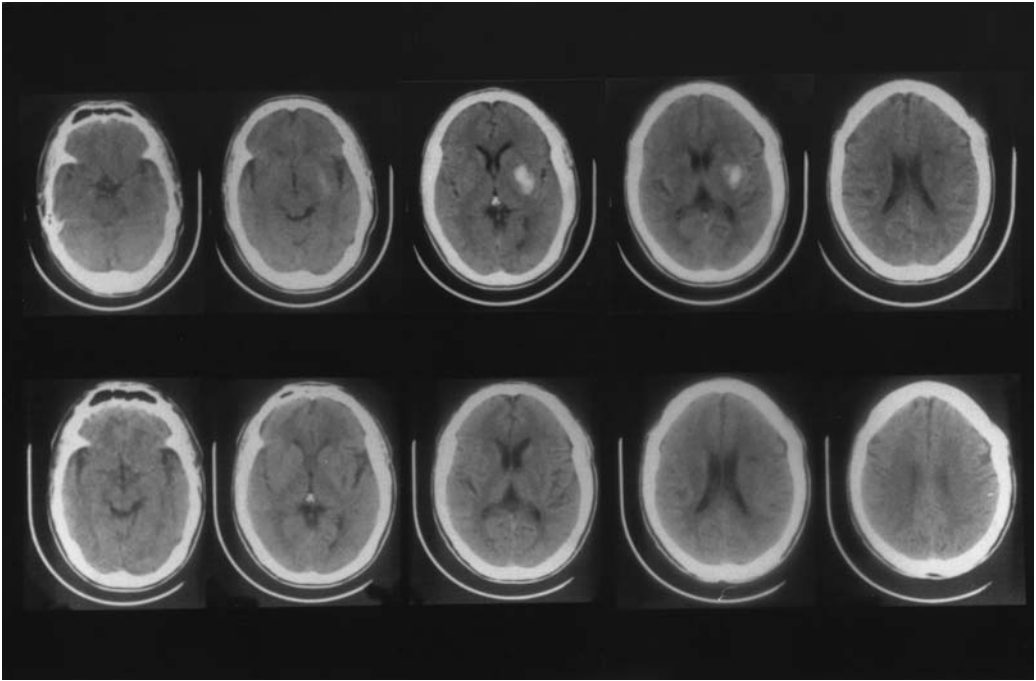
Computed tomographic scans of Pt. 1 (without aphasia) who had excellent performance on the Writing to Dictation of Sentences, Writing to Dictation of Words, and Spontaneous Writing of Name and Address, with left putaminal hemorrhage. Top: CT scan slices where hemorrhage was present at 8 days poststroke; the hemorrhage involved the putamen with slight extension into the posterior limb, internal capsule. Bottom: CT scan slices obtained at 2 months poststroke.
